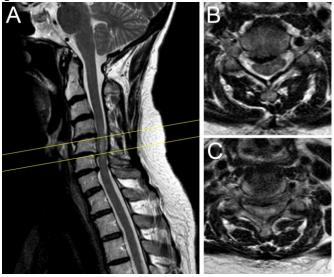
Preoperative sagittal T2 weighted MRI depicts severe spinal stenosis from C4-C6 with T2 hyperintense spinal cord signal (A). Axial T2-weighted images reveal moderate C4/5 (B) and severe C5/6 (C) spinal stenosis.
